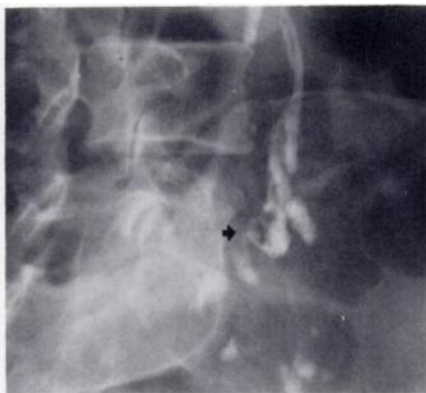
False-positive lymphangiogram. A, Definite filling defect in left common iliac node (arrow) on oblique view. B, CT through common iliac region. No evidence of adenopathy. At surgery, there was fatty replacement of nodes, but no tumor.
